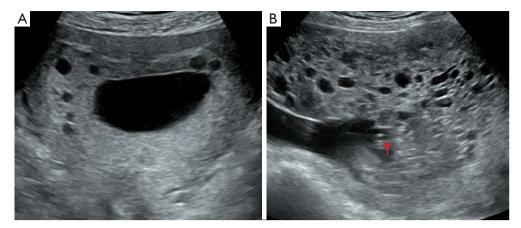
Case 1. (A) Ultrasound image at 13 weeks of pregnancy with PMD. Small cystic hypoechoic areas present within the placental substance. (B) Ultrasound image at 17 weeks of pregnancy with PMD. Gradual increase in cystic hypoechoic areas within the placental substance. The red arrow points to the umbilical cord insertion site, and the affected region is located at the entrance of the placental umbilical cord. PMD, placental mesenchymal dysplasia.
